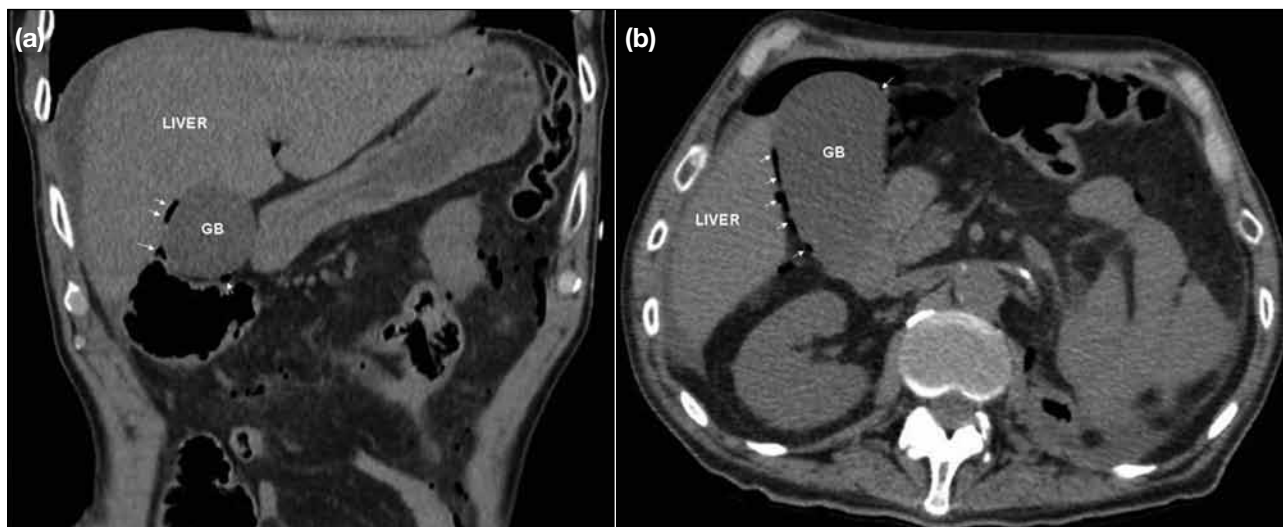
(a) Coronal and (b) axial reformats of unenhanced computed tomography of abdomen demonstrating free air (arrows) around distended gall bladder (GB).
